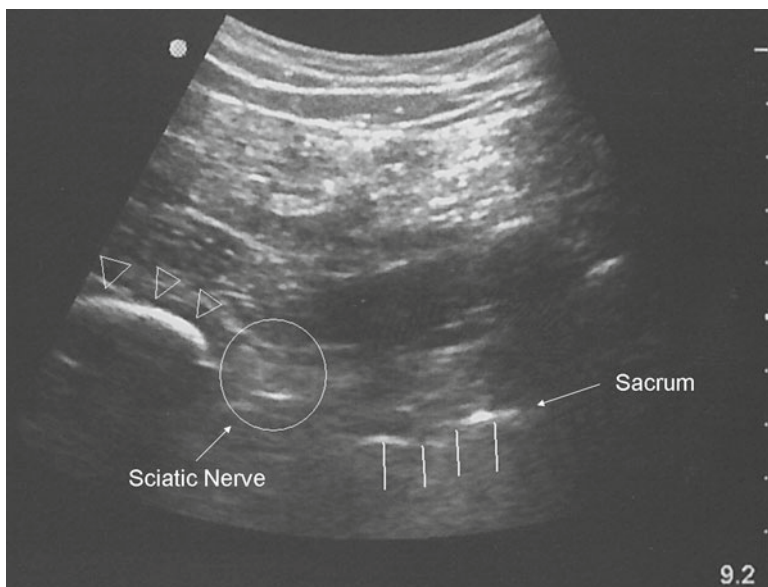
Ultrasound-guided parasacral approach. *Arrow heads* identify the ischial bone (IB) and *straight lines* identify the sacrum. The sacral plexus is marked by a *circle*
